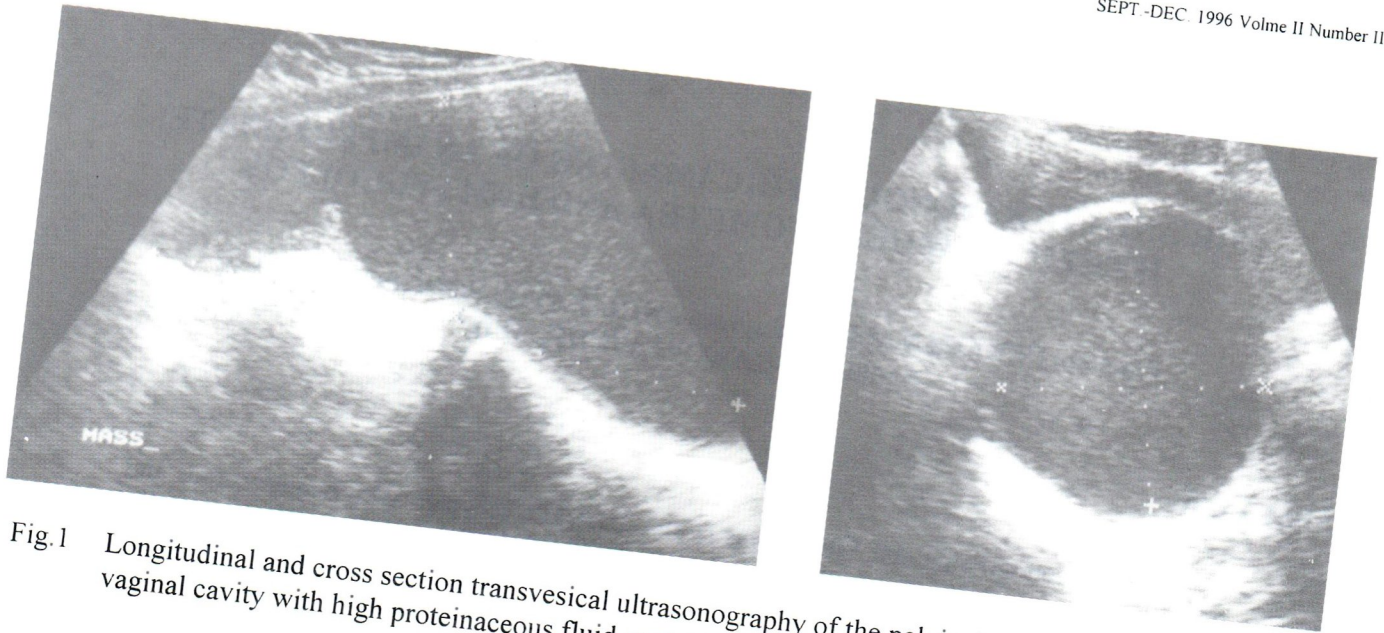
Longitudinal and cross section transvesical ultrasonography of the pelvis showed distended uterine and vaginal cavity with high proteinaceous fluid content.
